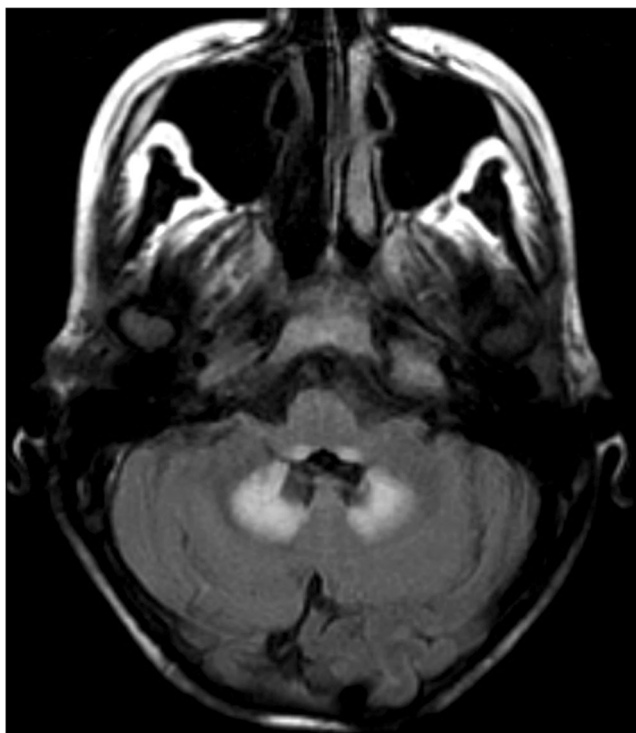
T2/FLAIR-weighted MRI of the brain shows hyperintensities in the dorsal medulla and in the dentate nuclei of the cerebellum in a patient taking metronidazole (500 mg every 8 h for 4 weeks) who developed ataxia, slurred speech, and bilateral dysmetria
